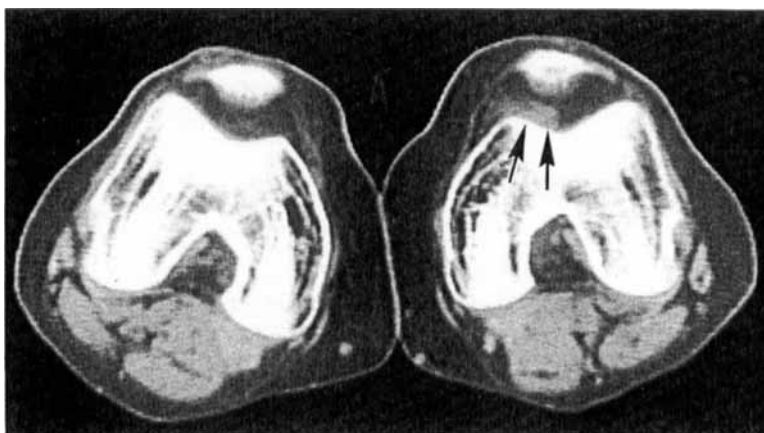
Computed tomogram in the horizontal plane at the level of the lower pole of the patella. The hemangioma is seen as soft tissue between the patella and the medial femoral condyle (arrows).
